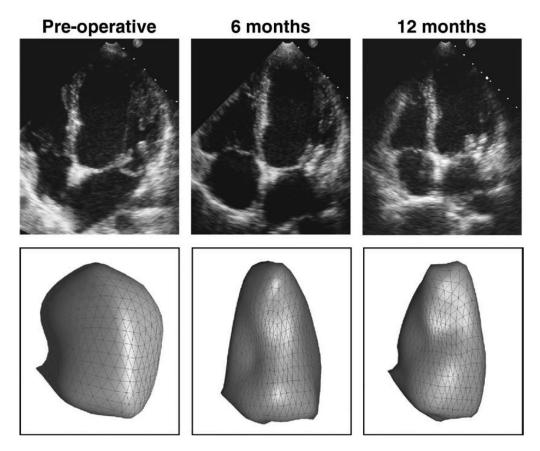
Example of ED 4-chamber views (top) and the corresponding LV endocardial surfaces (bottom) extracted from transthoracic echocardiographic data sets in a patient who underwent MV repair, before (left) and 6 months (center) and 12 months (right) after MV repair, showing decreased LV volume associated with changes in LV shape during follow-up.
